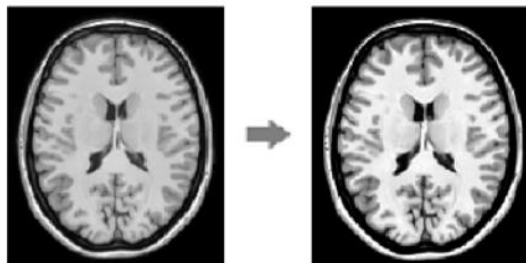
Normalization process in MRI image
